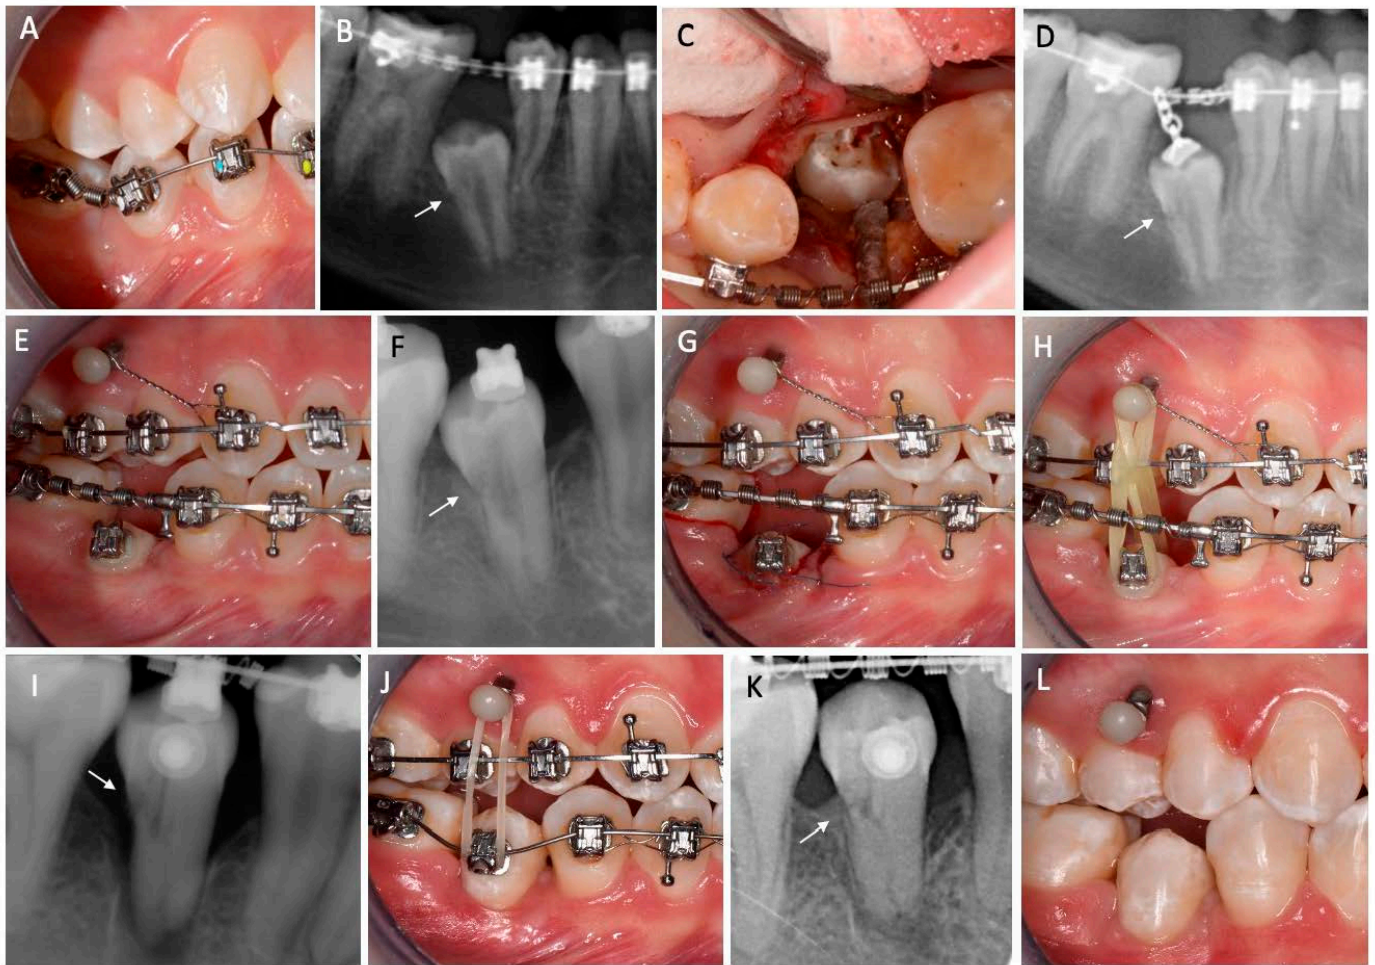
Orthodontic treatment progress of the impacted mandibular second premolar. (A) Open coil spring activation. (B) Radiograph showing no changes in impacted tooth position after space opening. (C) Surgical exposure of the impacted tooth. (D) Radiograph after surgical exposure and activation of traction shows no changes in impacted tooth position. (E) Next appointment after surgical luxation, bracket was bonded to the impacted tooth and micro-screw was inserted in the maxilla to pull the tooth towards the occlusal plane (F) Radiograph after surgical luxation of the impacted tooth, showing eruption. (G) The impacted tooth after repeated surgical luxation. (H) No visible response to orthodontic traction. (I) Radiograph showing the impacted tooth immediately after reimplantation. (J) Mandibular second premolar attached to the archwire and traction activated using mini-screw. (K) Radiograph taken six months after reimplantation. (L) Photo showing the final position of the tooth. (B,D,E,I,K) White arrows show the site of external cervical resorption (ECR). As the patient expressed her wish to cease the treatment as soon as possible, the tooth was luxated and positioned 6 mm coronally and passively fixed to the archwire (I,J). During the following two monthly appointments, no vertical movement of the tooth was observed.
